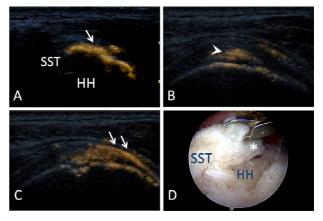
Small full-thickness tear in a 56-y-old woman. (A) Percutaneous ultrasound-guided subacromial bursography image revealed that hyper-echoic contrast agent was dispersed only within the bursa outlining an irregular superior bursal cuff surface (↑); it did not leak into the tendon in the long-axis view. (B) Percutaneous ultrasound-guided tendon lesionography image revealed that hyper-echoic contrast agent was localized within the tendon (arrowhead) in the long-axis view. (C) As the amount increased, the contrast agent filled and outlined the tear area, then leaked into the glenohumeral joint cavity and finally into the irregular bursa (↑↑) in the long-axis view. (D) Arthroscopy confirmed a small full-thickness tear (*) with severe synovial proliferation on the bursal-side cuff.
